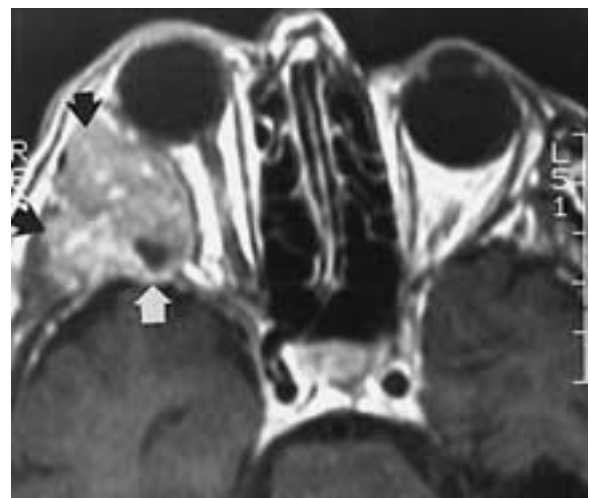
Orbital metastasis from a malignant histiocytoma. Axial-enhanced T1-weighted MR image shows a metastatic deposit involving the lateral wall of the right orbit (arrows).
